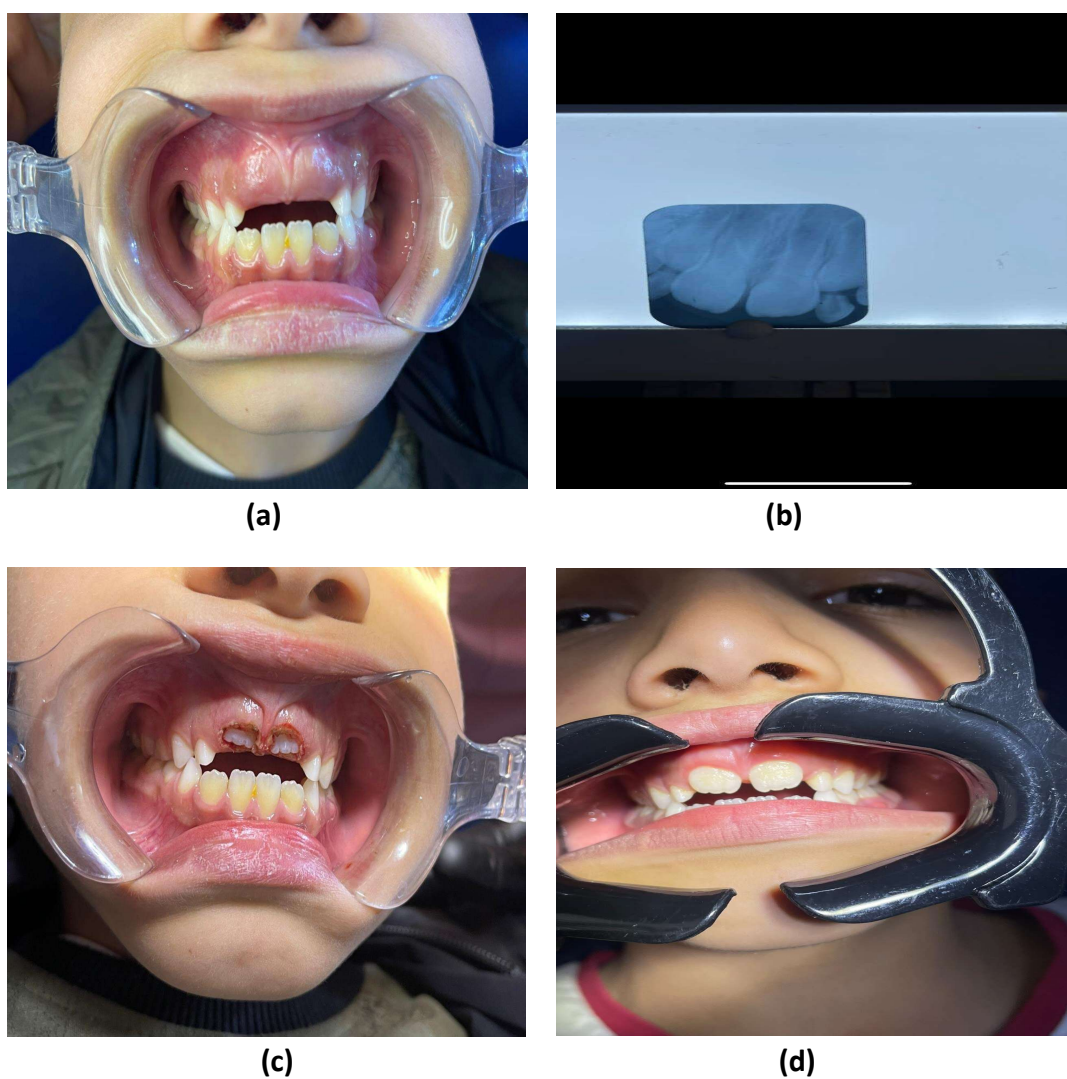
Laser excision technique of gingival fibromatosis in central incisor region for 9-year-old male patient: (a) Pre-operative clinical feature, (b) Pre-operative periapical radiograph, (c) Immediately postoperative view and (d) Complete healing and eruption of affected teeth after four weeks.
